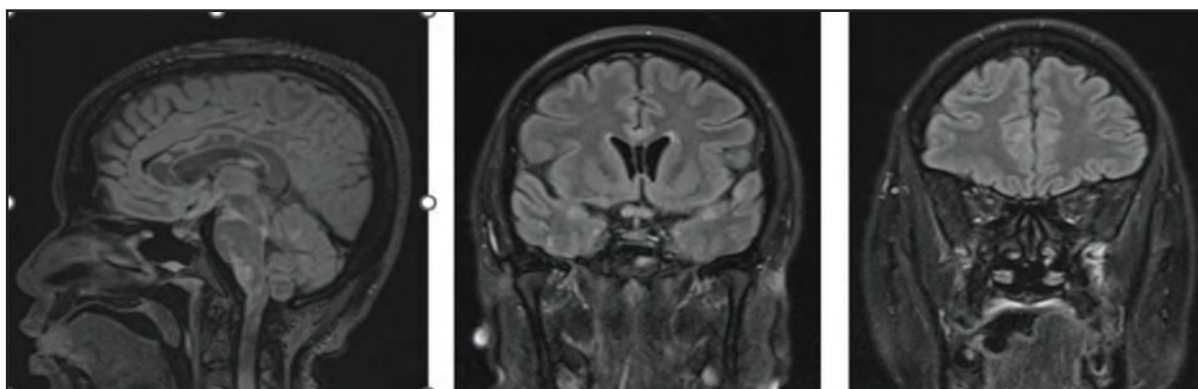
Sagittal FLAIR brain images showed patchy hyperintensities at corpus callosum (A), bilateral medial temporal lobes (B), frontal region (C)
